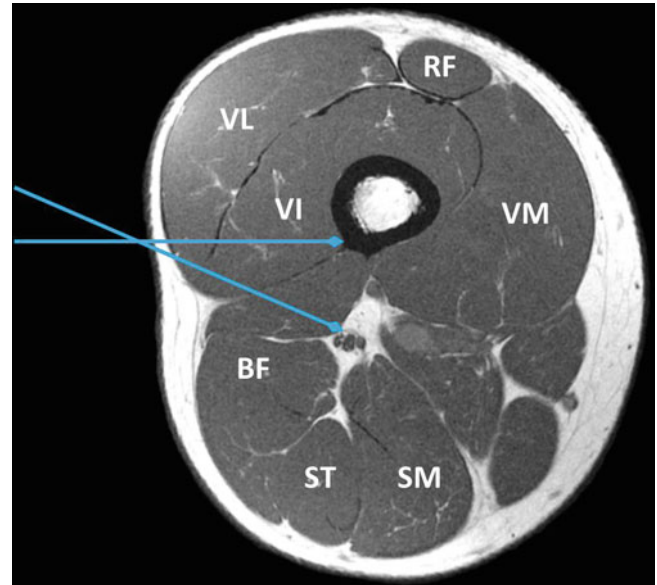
MRI cross section of the thigh indicating the lateral approach to the sciatic nerve. The needle is initially advanced perpendicular to the skin to contact the femur, before being redirected posteriorly at approximately 30° angle to reach the sciatic nerve. *BF* biceps femoris, *RF* rectus femoris, *SM* semimembranosus, *ST* semitendinosus, *VI* vastus intermedius, *VL* vastus lateralis, *VM* vastus medialis
